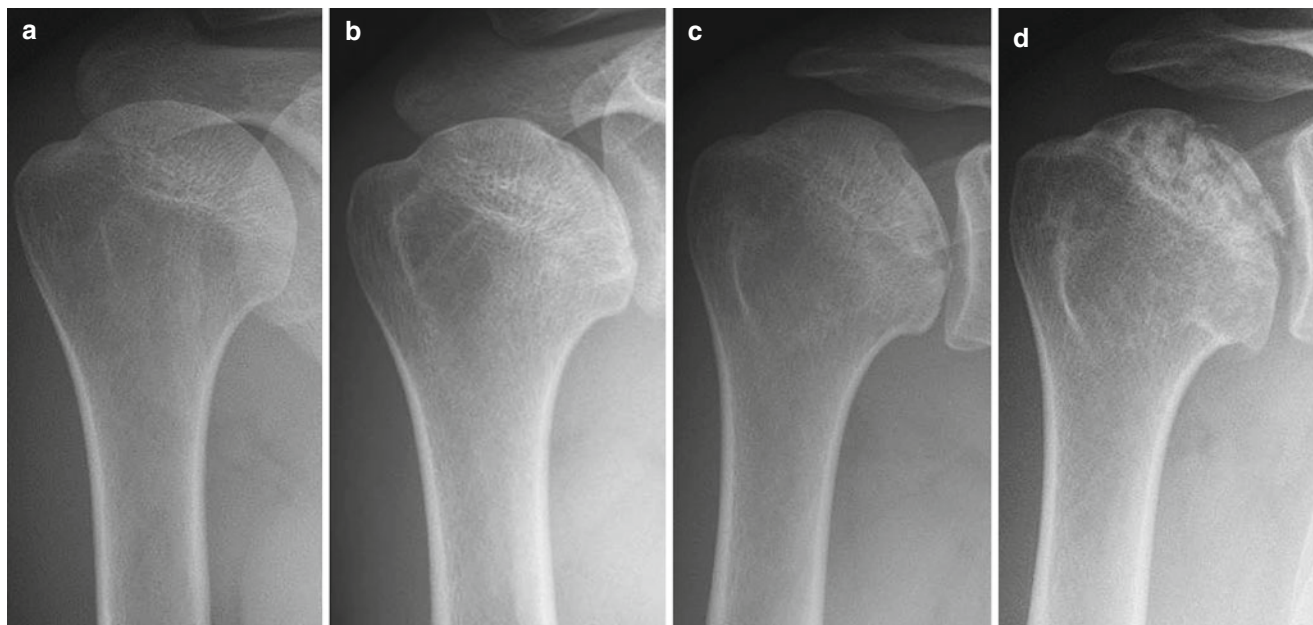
Plain radiographs of ONHH. No radiologic abnormality is seen in stage I (a). An early sign of subchondral fracture is seen in stage III (b). Flattening of the humeral head follows (c), and fragmentation of the necrotic lesion may be seen later (d)
